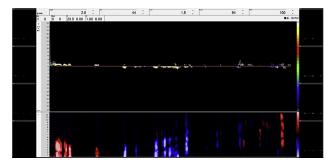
After endoscopic band ligation, the Doppler wave disappeared.
